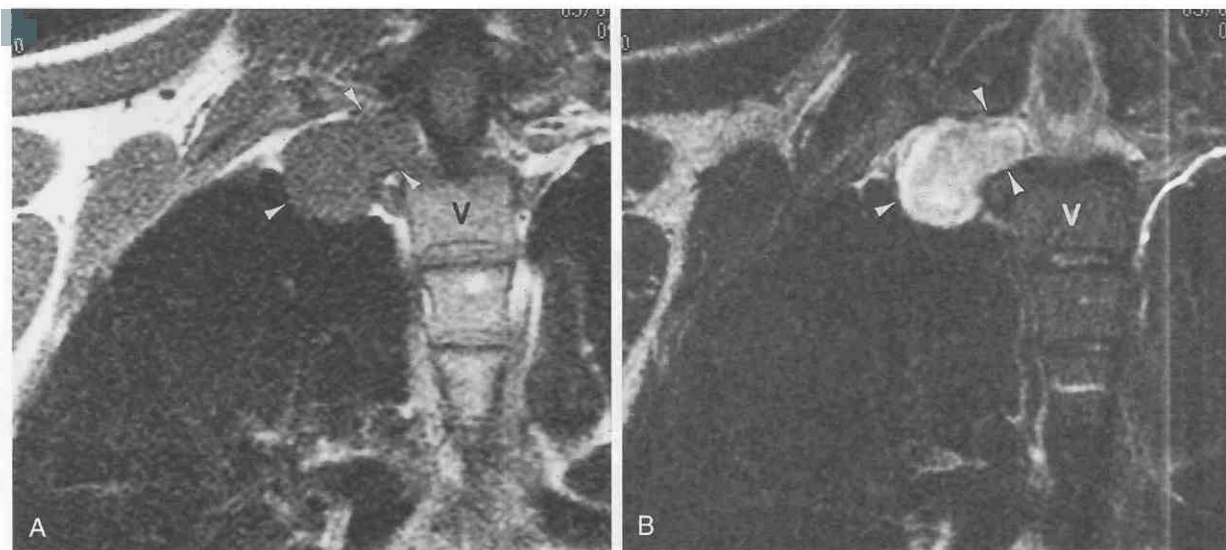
Neurofibroma. A, Coronal T1-weighted MR image shows a lobular mass extending into the intervertebral foramina (arrowheads). B, Coronal gadolinium-enhanced MR image shows heterogeneous enhancement within the mass (arrowheads). V, vertebral body. (From Rossi SE, Erasmus JJ, McAdams HP, Donnelly LF: Thoracic manifestations of neurofibromatosis-I. *AJR Am J Roentgenol* 173:1631–1638, 1999.)
